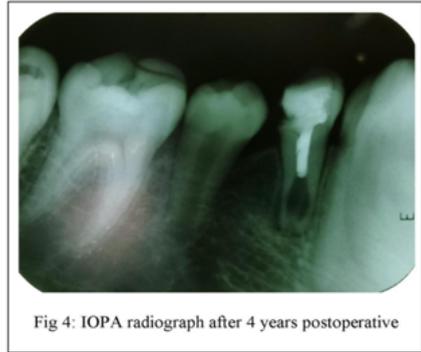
IOPA radiograph after 4 years postoperative
